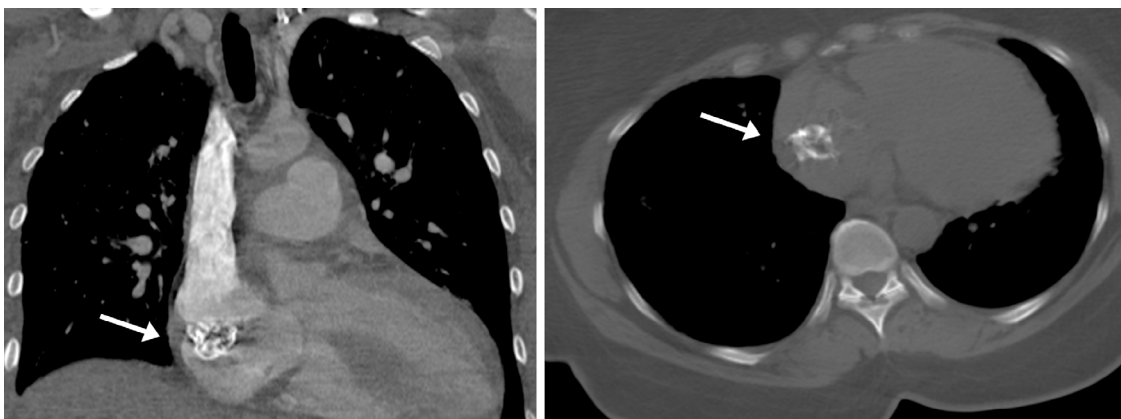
CT imaging showing highly calcified RA mass (arrow).
